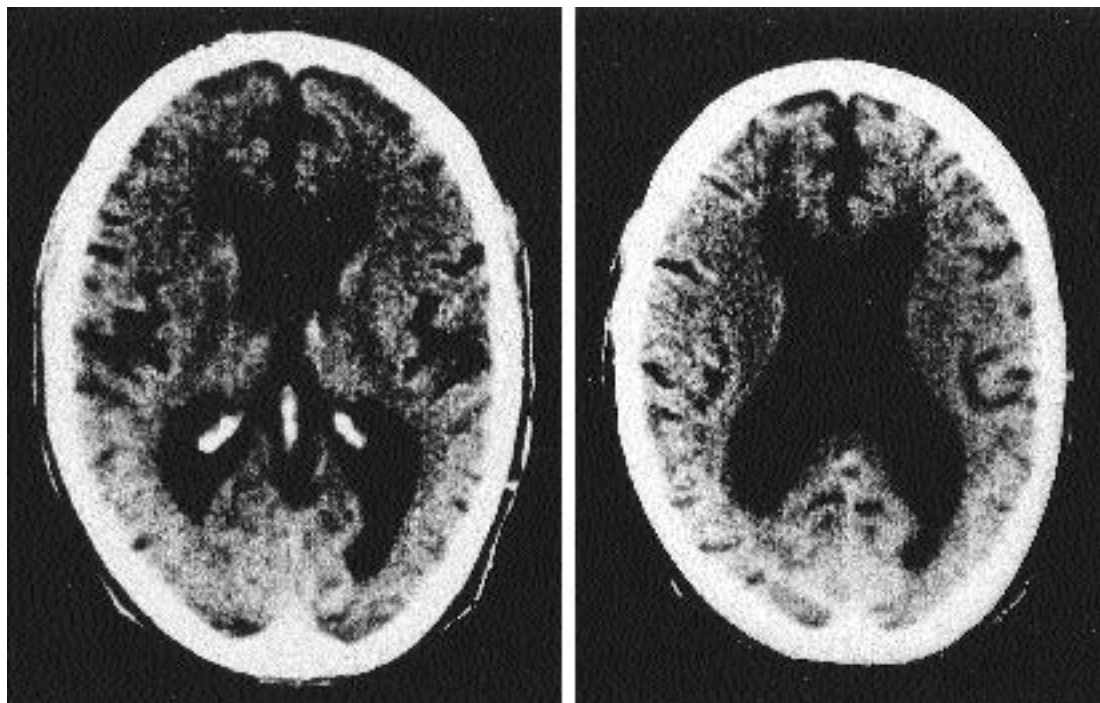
CT scan of same patient as in Figures 13.5 and 13.6 made at time of second EEG shows dilated ventricles and prominent sulci, indicating cerebral atrophy.
